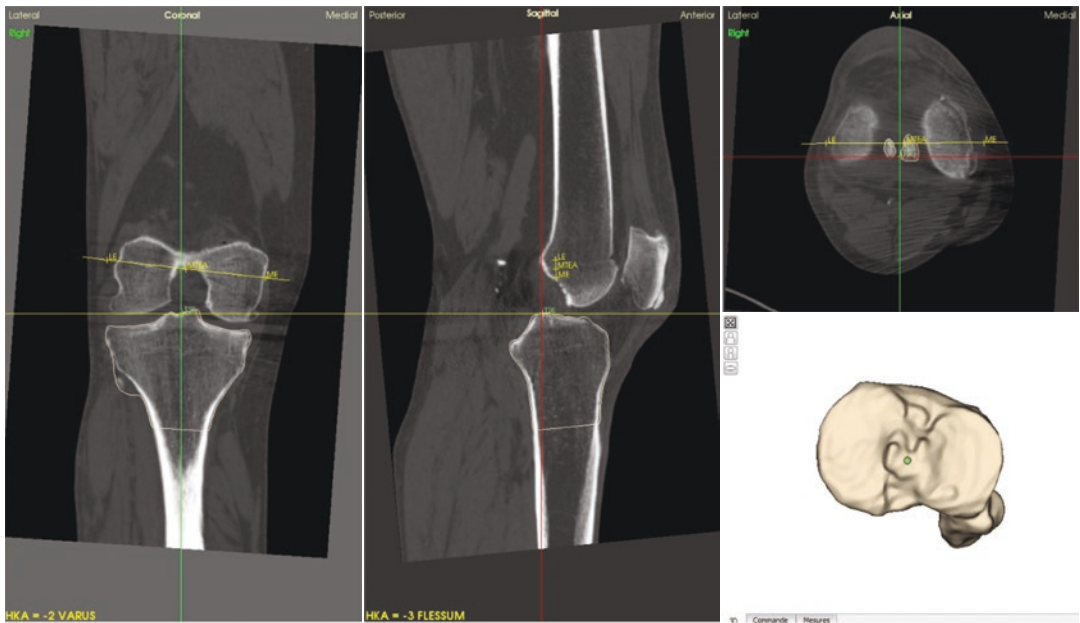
CT slices of a patient's knee and the proximal tibia center selected
